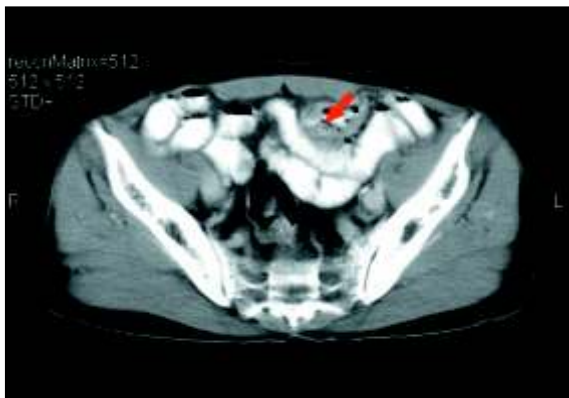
CT scan abdomen showing short segment of asymmetrical bowel wall thickening of small bowel (arrow).
